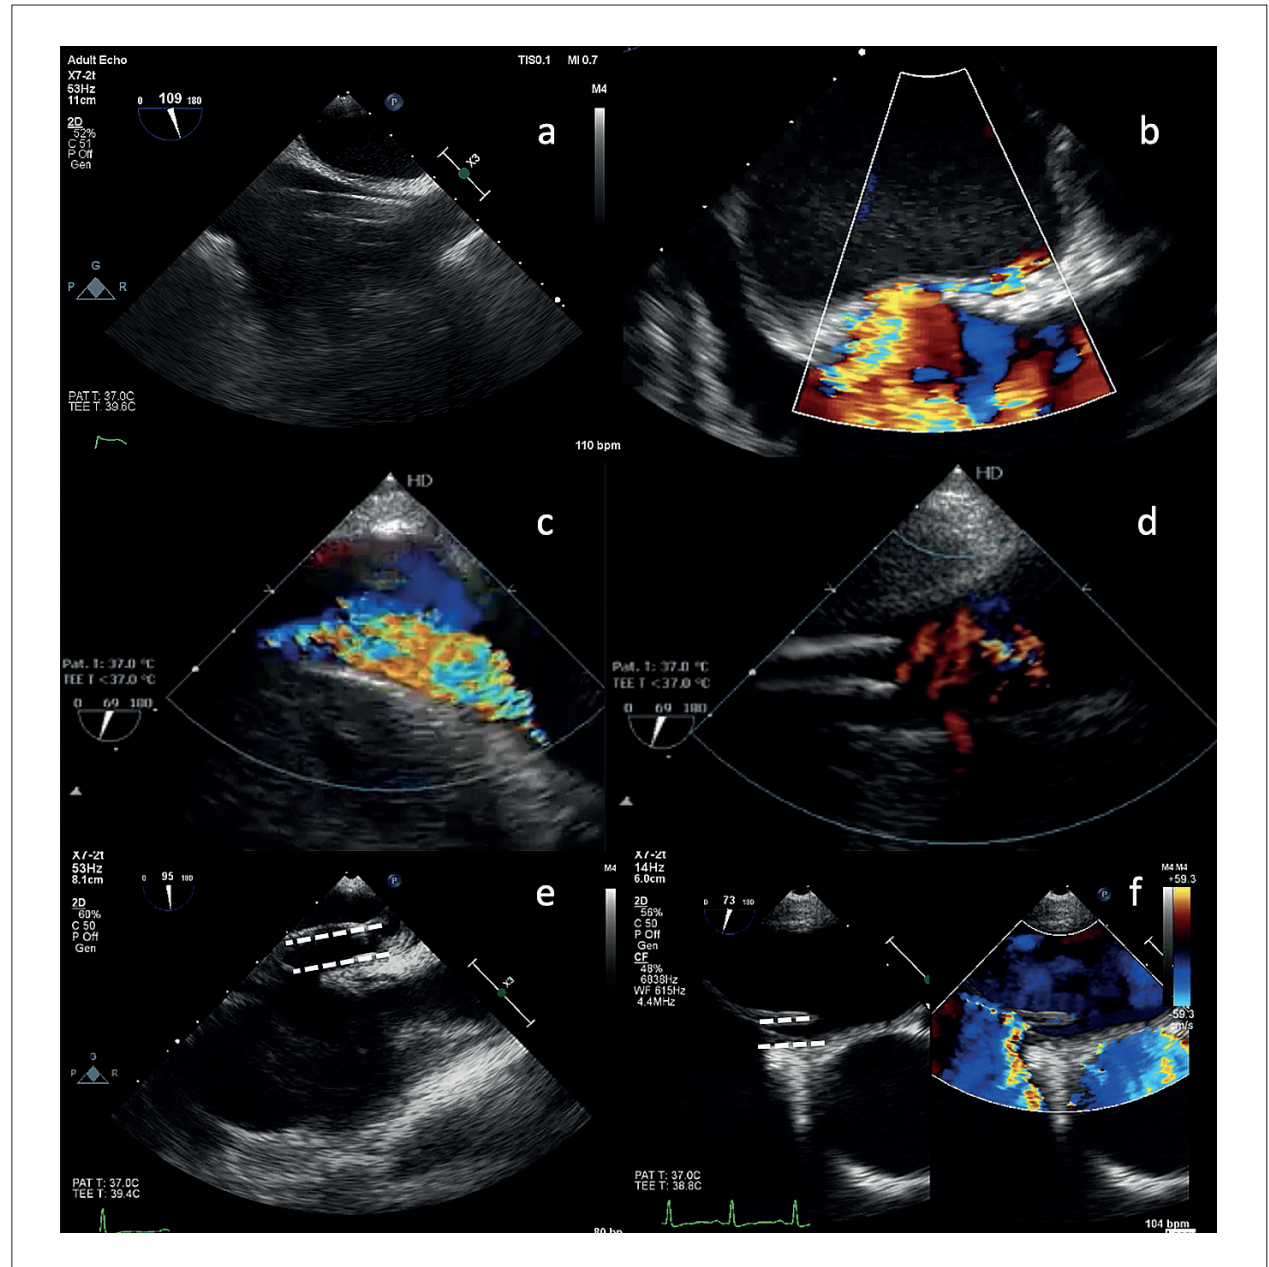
Various situations demonstrating the role of TEE in the evaluation of patients on VA-ECMO. (a) Bicaval view showing the venous drainage cannula in the correct position, with the tip at the junction of the SVC and the RA. (b) Modified bicaval view in a patient presenting with difficulty in oxygenation during the weaning process. Color Doppler shows the presence of a patent foramen ovale with a right-to-left shunt explaining the hypoxia. (c) Transgastric view of the IVC with color Doppler showing signs of VV-ECMO recirculation (turbulent flow due to the short distance between the tips of the drainage and return cannulas, causing the drainage cannula to aspirate blood from the return cannula tip). (d) Transgastric view of the IVC in the same patient on VV-ECMO after repositioning the drainage cannula a few centimeters lower. Color Doppler shows linear flow, indicating less recirculation. (e) and (f) Bicaval view at the mid-esophageal level in a patient on VA-ECMO showing the drainage cannula crossing the interatrial septum through the fossa ovalis tunnel, creating a small iatrogenic ASD. ASD: atrial septal defect; IVC: inferior vena cava; RA: right atrium; SVC: superior vena cava; TEE: transesophageal echocardiography; VA-ECMO: venoarterial extracorporeal membrane oxygenation; VV-ECMO: venovenous extracorporeal membrane oxygenation.
